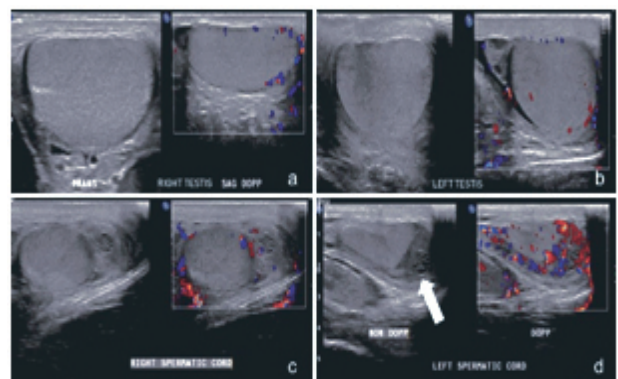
Ultrasound findings in a 43-year-old male testis: (a) Normal right testis, (b) enlarged left testis with decreased vascularization, (c) normal right spermatic cord, and (d) 'whirlpool' sign (arrow) in the left spermatic cord.
